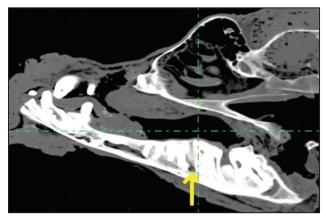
CT image of dorsal plane showing posterior mental foramen situated just caudal to the alveoli of 1st molar tooth.
